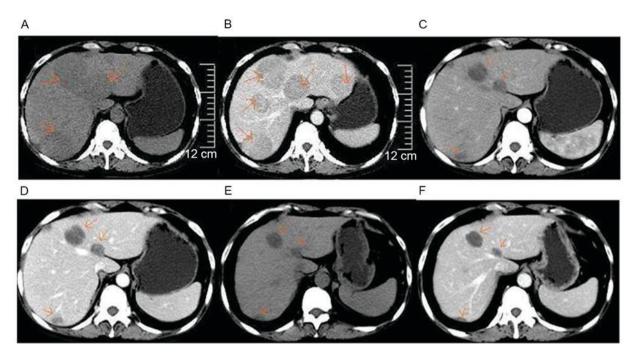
Upper abdominal computed tomography scan images prior to and following lenalidomide therapy. (A) Non-enhanced; (B) enhanced, prior to lenalidomide therapy (25 February 2014). Multiple round-like and well-defined lesions of distinct sizes with low attenuations were present in hepatic parenchyma. Following administration of contrast materials, the enhancements of lesions were mild and heterogeneous. (C) Non-enhanced; (D) enhanced, following four cycles of RCd regimen therapy (1 July 2014). Decreased size of round-like lesions were observed in hepatic parenchyma, compared with (A and B). (E) Non-enhanced; (F) enhanced, following five cycles of RCd regimen (25 August 2014). Further decreased size of round-like lesions were present in hepatic parenchyma, compared with (C and D). RCd regimen, lenalidomideat 25 mg on days 1-21, cyclophosphamide at 50 mg on days 1-21 and dexamethasone at 20 mg on days 1, 8, 15 and 22, with 28 days/cycle. The arrow in each of the images point to the plasmacytoma in the liver.
